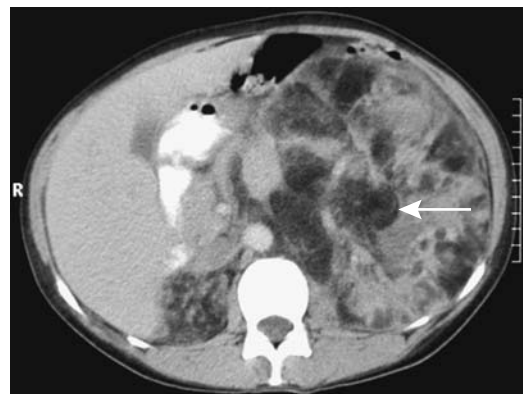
Lipomatosis in a woman with tuberous sclerosis. Computed tomography reveals numerous fat-density tumors and small bowel intussusception (arrow). (Courtesy of Algidas Basevicius, M.D., Kaunas Medical University, Kaunas, Lithuania.)
